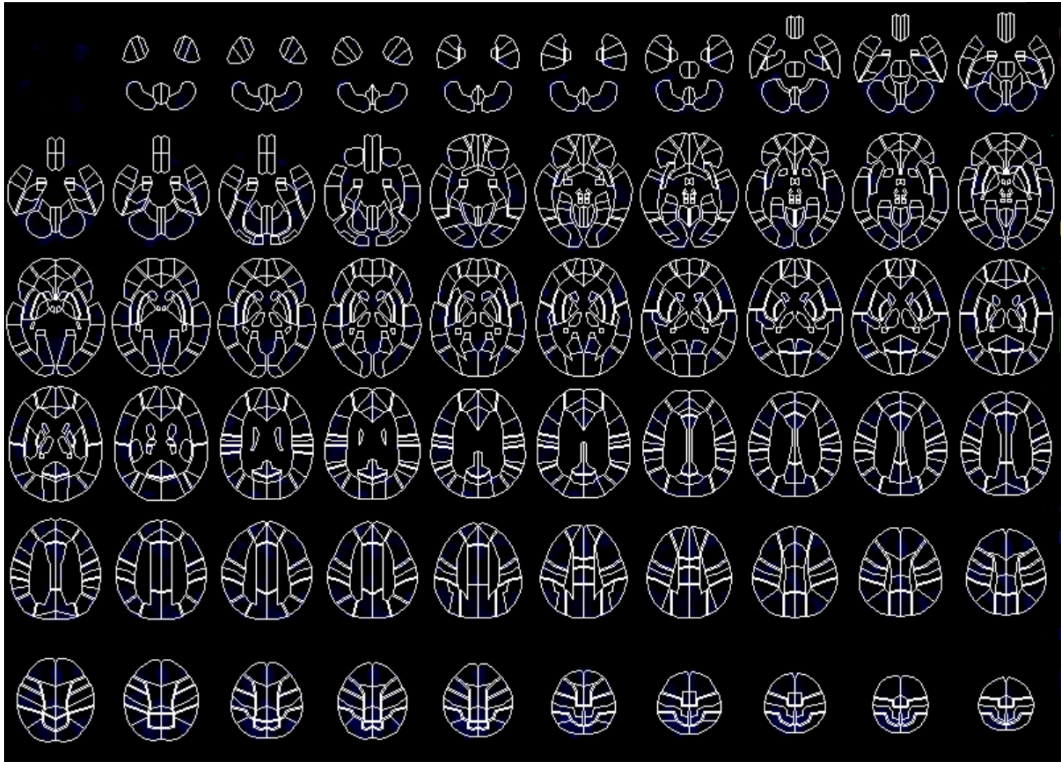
Fine stereotactic region of interest (ROI) template (SRT) image composed of 52 areas of ROI in Single Photon Emission Computed Tomography (SPECT) study.
